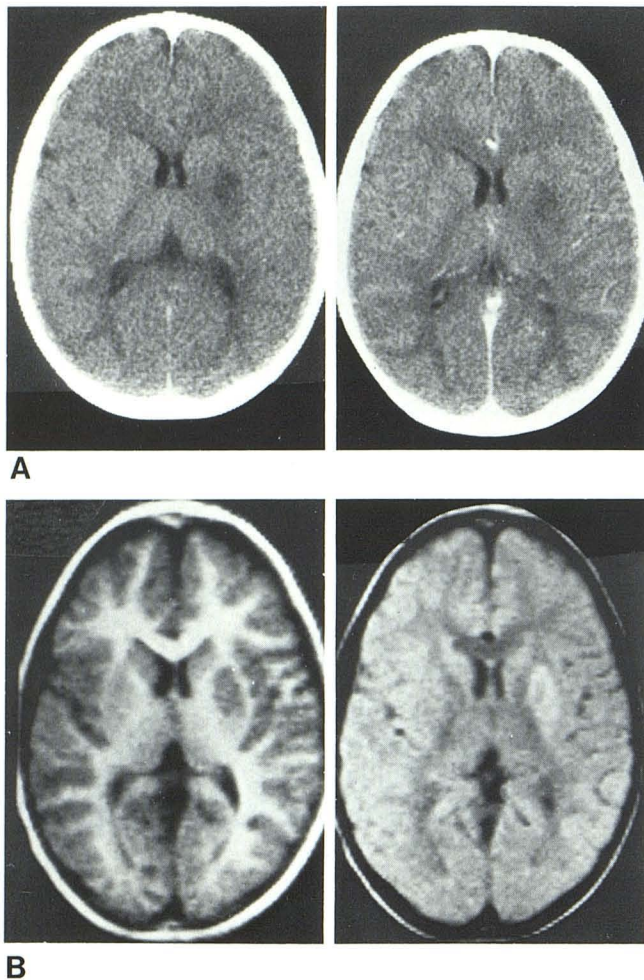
Acute basal ganglia infarct. A, CT at level of frontal horns shows hypodense lesion in left globus pallidus (left), which does not enhance after intravenous contrast administration (right). B, NMR images 4 days after stroke depict lesion as low-intensity focus on IR image due to its lengthened T_1 (left), whereas it shows as a high-intensity focus on second echo SE image due to its long T_2 .
